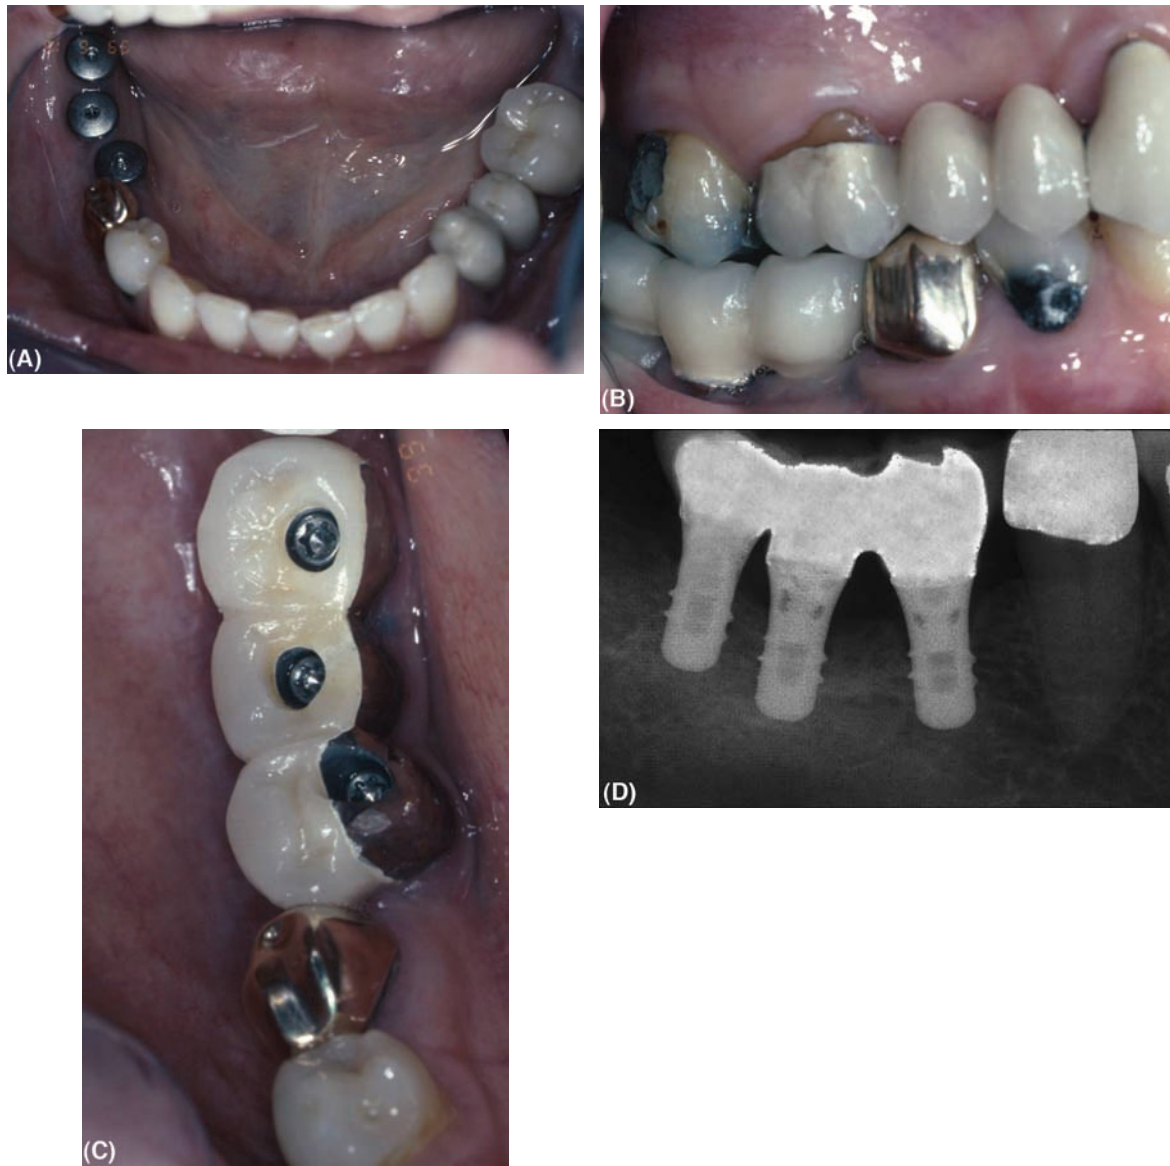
A posterior bridge supported by Straumann implants: (A) Three healing abutments are visible. (B) The completed bridge. (C) Occlusal view—screw retention has been used. (D) A periapical radiograph taken at the end of treatment.
